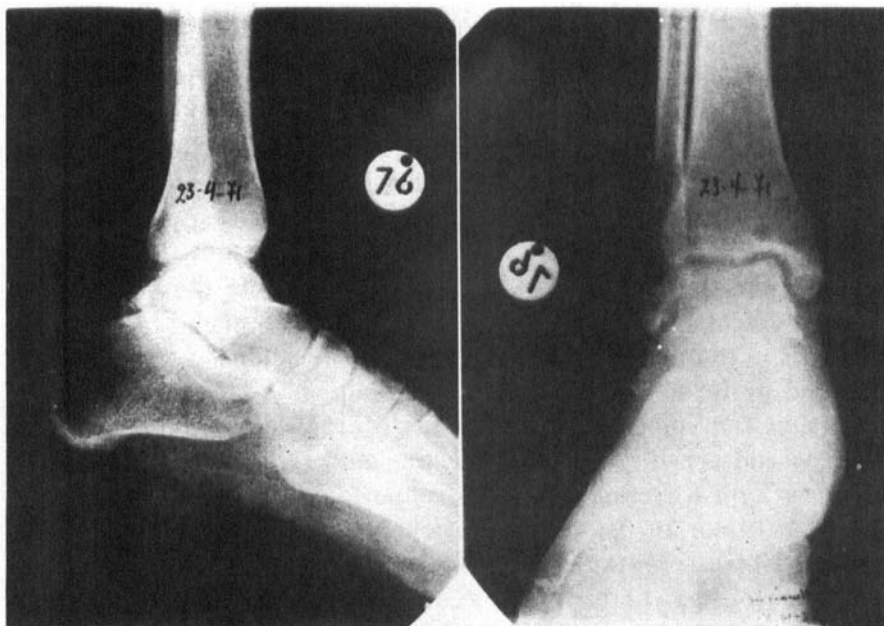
Lateral and antero-posterior radiographs showing only slight osteoarthritis of the subtalar joint seven years after avascular necrosis of the body of the talus following a neck fracture-dislocation. The repair process of the dead bone of the body has almost been completed.
